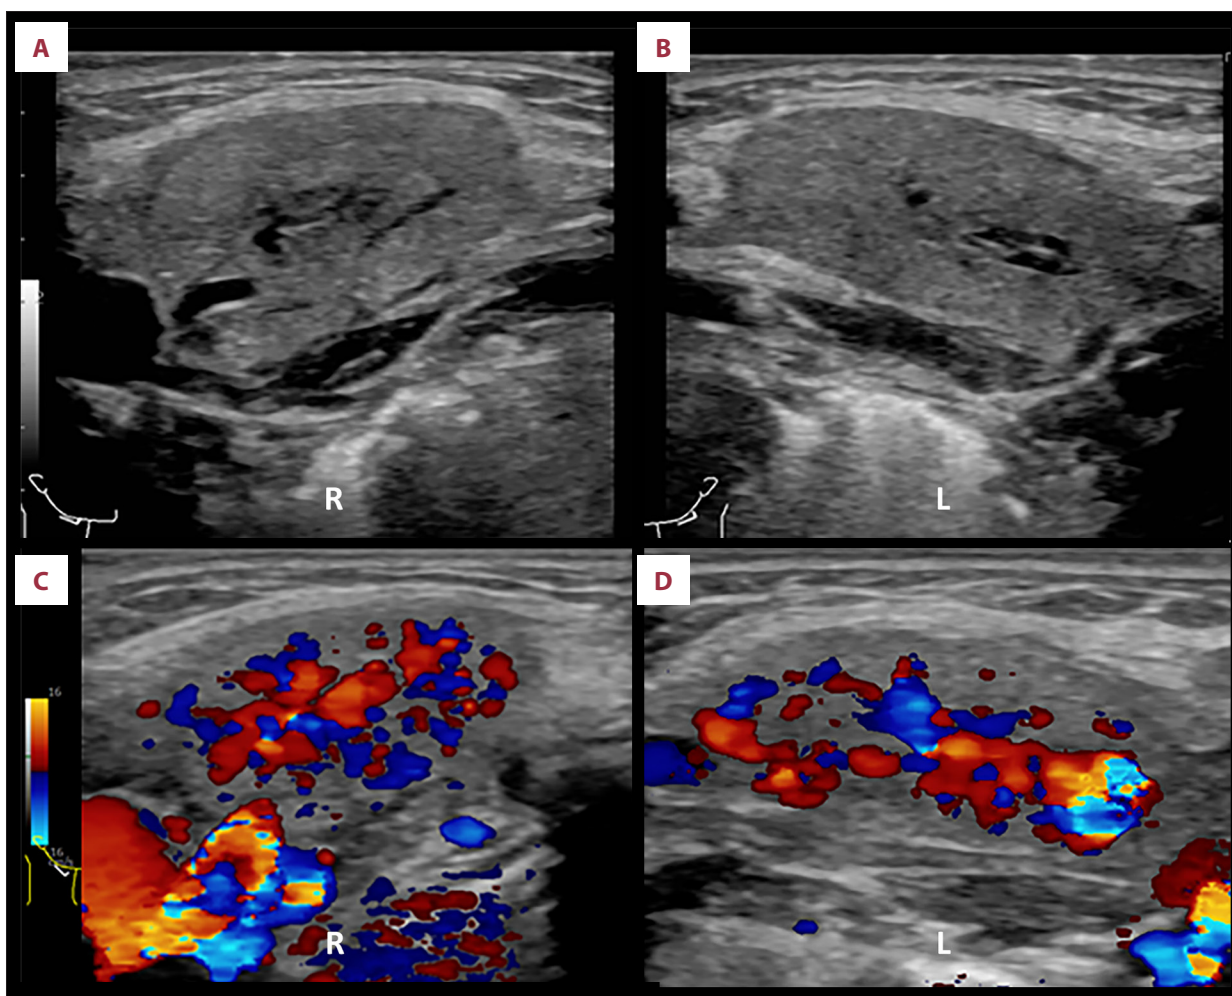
Ultrasonographic images of the submandibular glands obtained 18 hours after contrast administration. (A, B) Gray-scale images of the right (A) and left (B) submandibular glands demonstrate mild heterogeneous parenchymal echotexture with mild intraglandular ductal dilatation. (C, D) Color Doppler images demonstrate increased parenchymal vascularity within the right (C) and left (D) submandibular glands.
